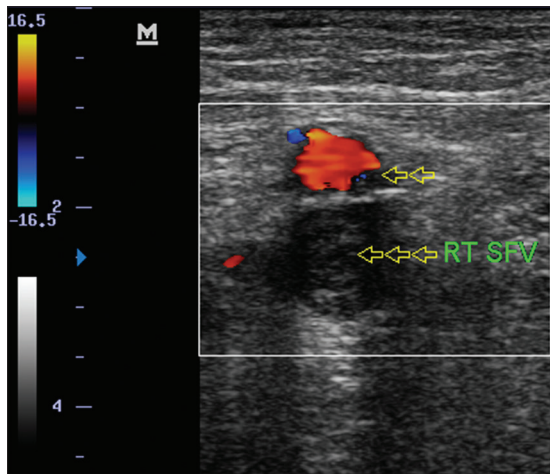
Axial section of color Doppler sonogram of the groin showing mixed echogenic luminal filling, rigidity, and absence of blood flow in the right superficial femoral vein in a patient with acute limb swelling
